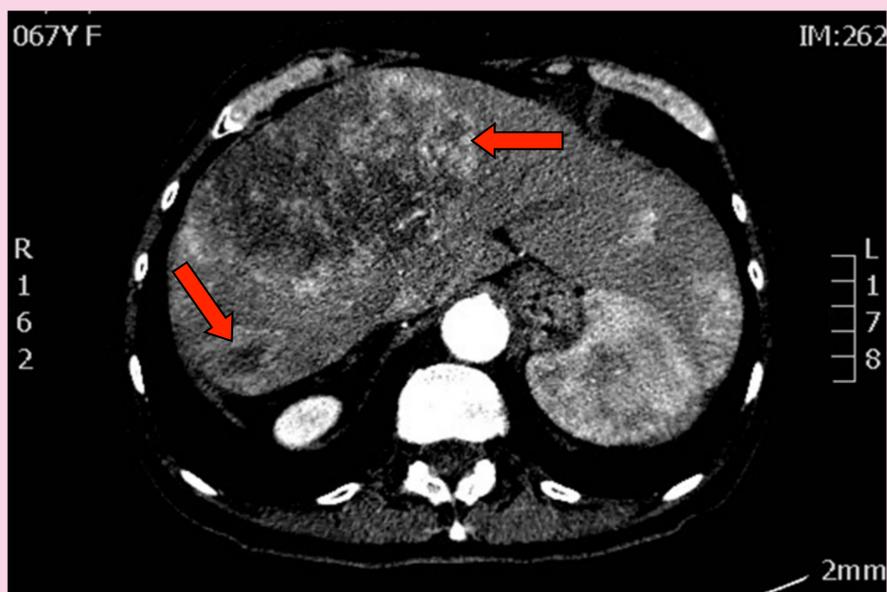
CT abdomen showing multiple liver lesions
